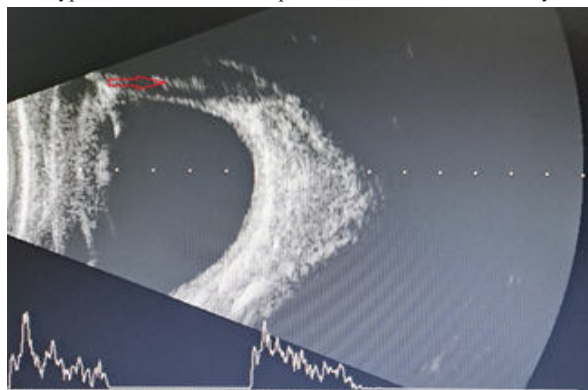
Ultrasound B scan of left eye demonstrating a hypoechoic area in superior rectus muscle with a hyperechoic centre (red arrow).
